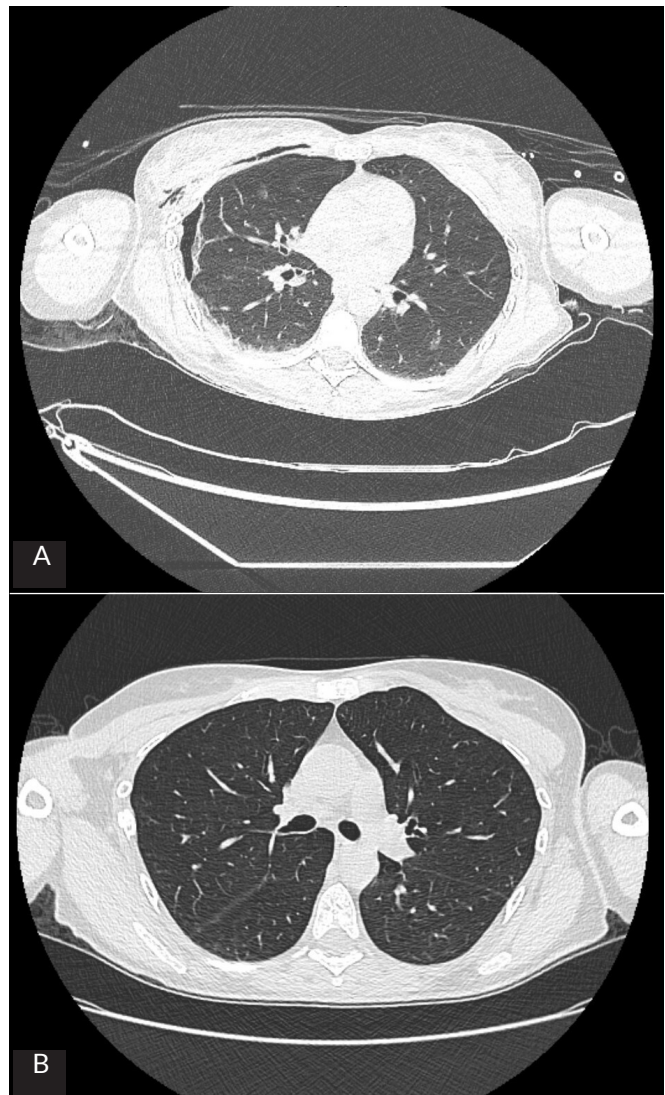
Case 8. Computed tomography findings. A. On admission. B. At discharge
